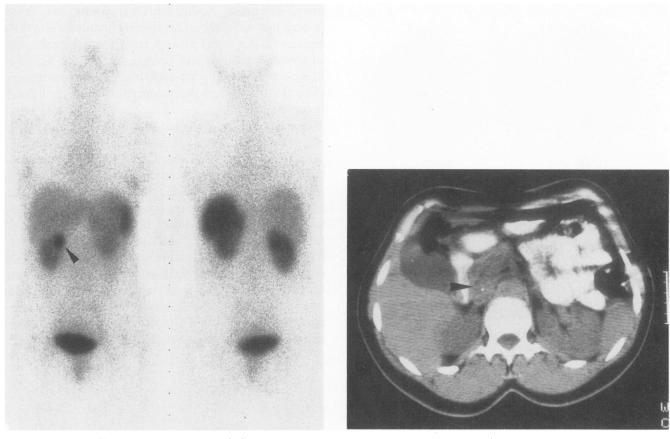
(Left) Whole-body SRS in a patient with the Zollinger-Ellison syndrome (patient 2). Left ventral view, right dorsal view. Nonspecific enhancement to the liver, spleen, kidneys, and bladder. The gastrinoma (diameter, 14 mm) localized within the pancreatic head is shown at the left, near the upper pole of the right kidney (arrowhead). (Right) Corresponding CT scan of the pancreatic head showing the area where the gastrinoma was found at surgery (arrowhead). No suspicious lesions in the area of the pancreatic head could be identified on CT scan.
